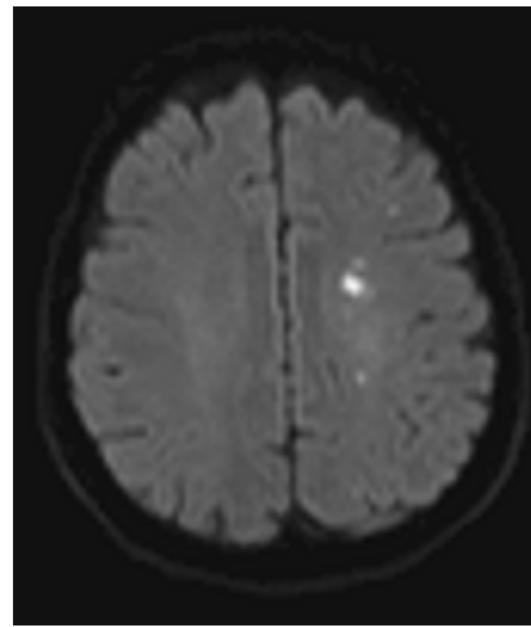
Axial DWI sequence showed restricted diffusion on watershed infarcts.
